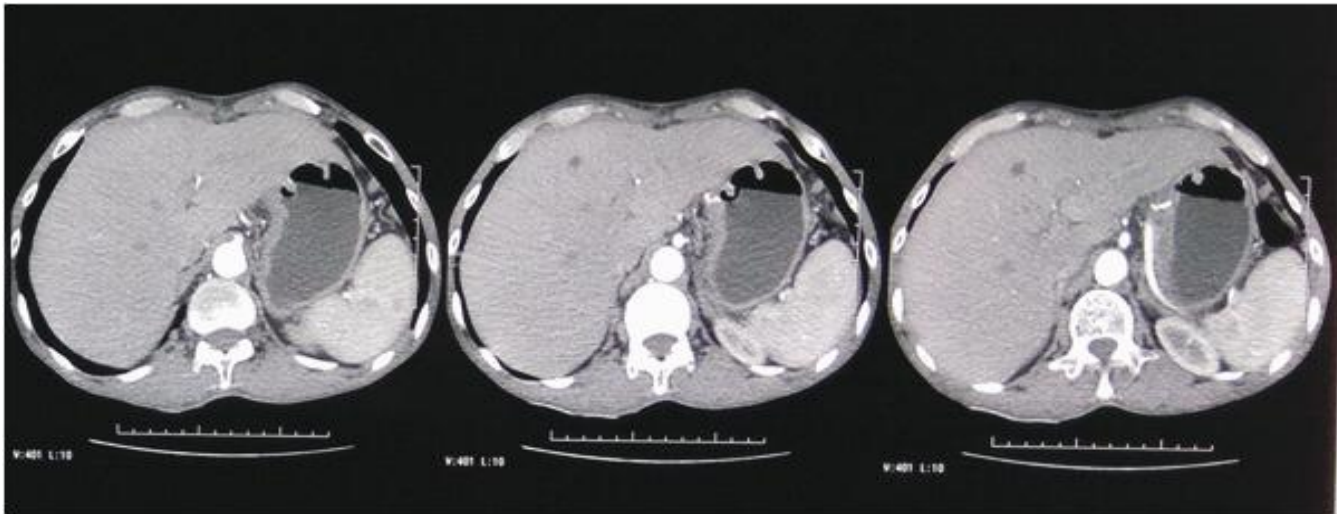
Computed tomography scan of abdomen with oral contrast demonstrates evidence of enhancing irregular thickening in the antrum
